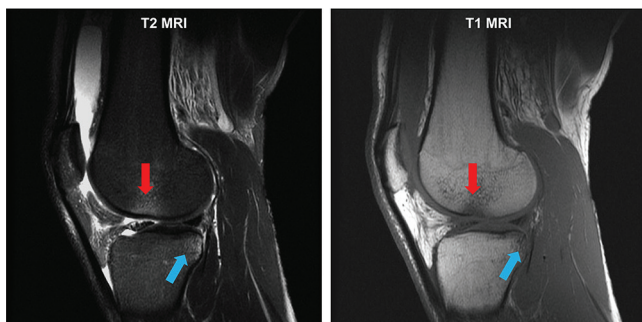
T2-weighted magnetic resonance imaging (MRI; left) and corresponding T1-weighted MRI (right). Arrows indicate positions of the femoral and tibial bone bruises. Note that the epicenters of the bone bruises are more apparent on the T1 images, whereas the bruises appear more diffuse on the T2 images.
